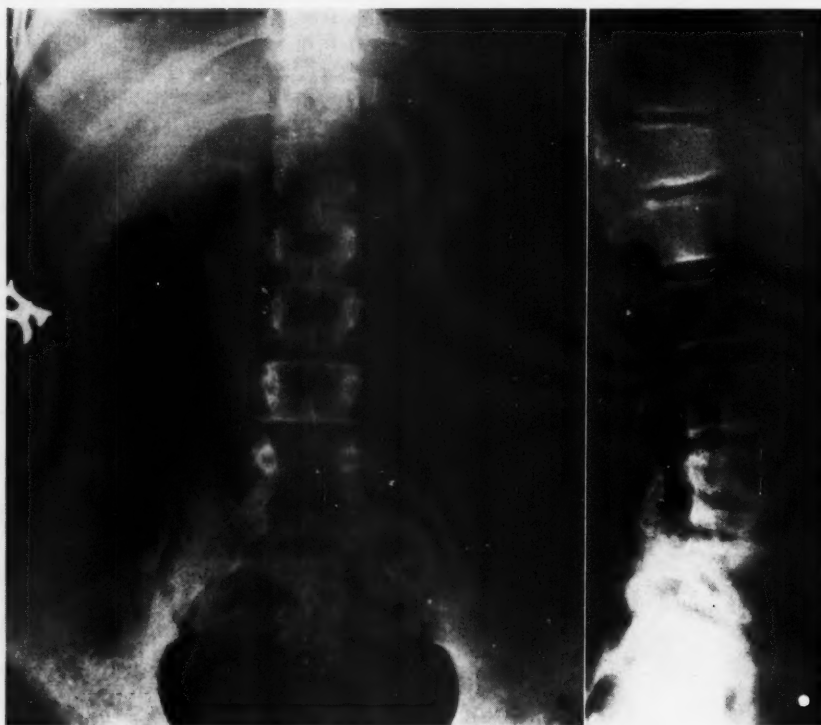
(Left) X-ray of the girl in Fig. 1, showing minor osteoporosis, tiny 12th ribs and only 4 lumbar vertebrae.
